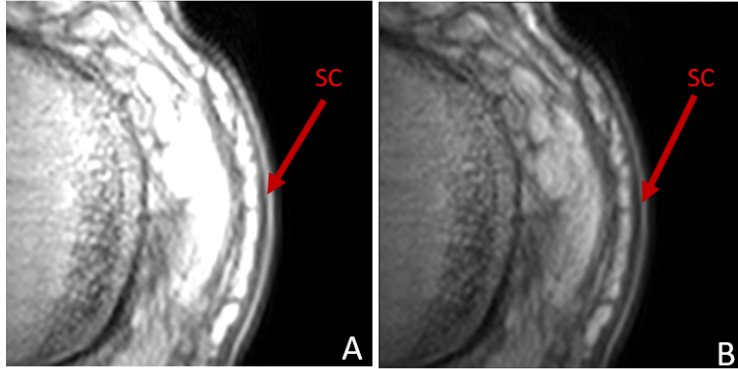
Intensity value change in SC layer of MRI image
